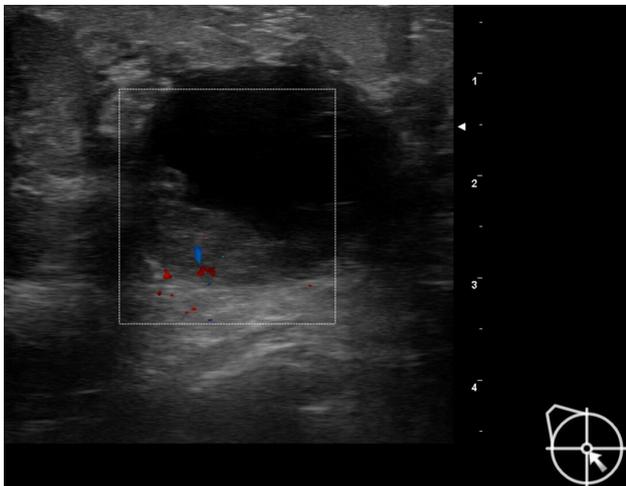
Breast ultrasound. Image of the cystic lesion of the right breast.
